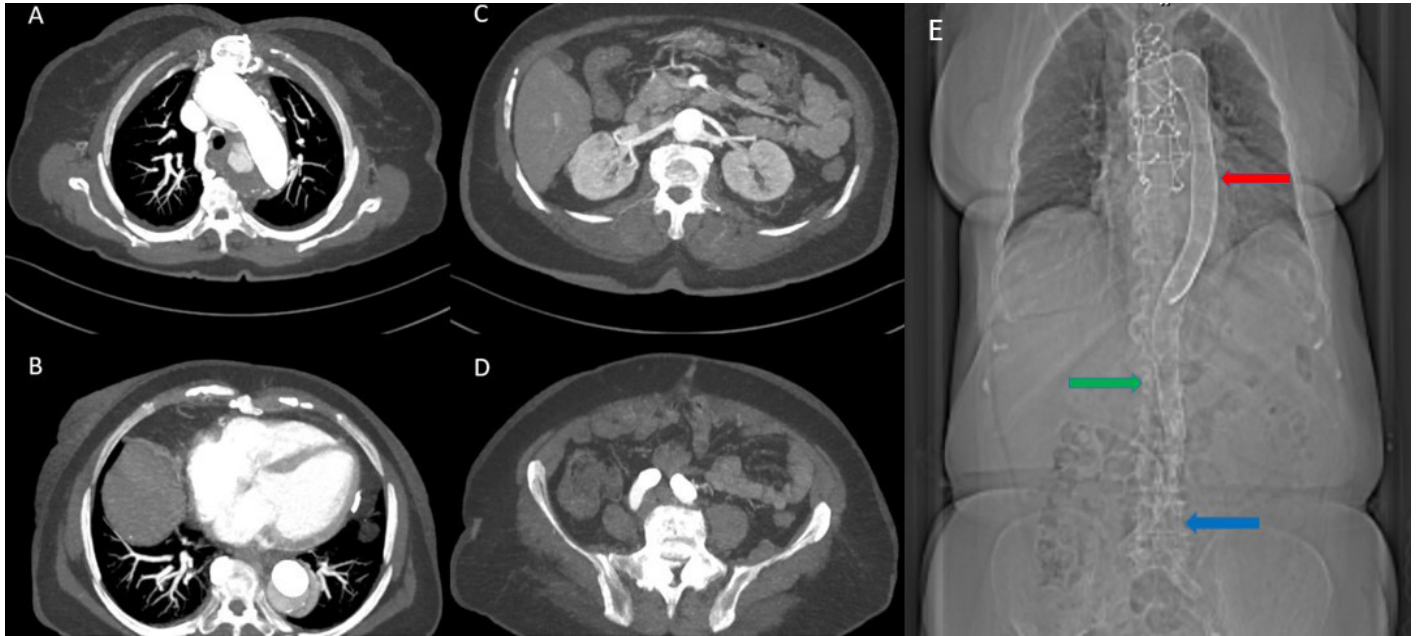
Sixth month computed tomography image. Levels of arcus aorta (2A), thoracic aorta (2B), renal arteries (2C) and iliac arteries (2D). Note the decreased flow and thrombus formation around the stents. Figure 2E shows direct radiography of the multilayer stent placed from the aortic arch to the bilateral iliac artery in tomography: Red arrow indicates thoracic stent, green arrow indicates abdominal and blue arrow indicates iliac stents
